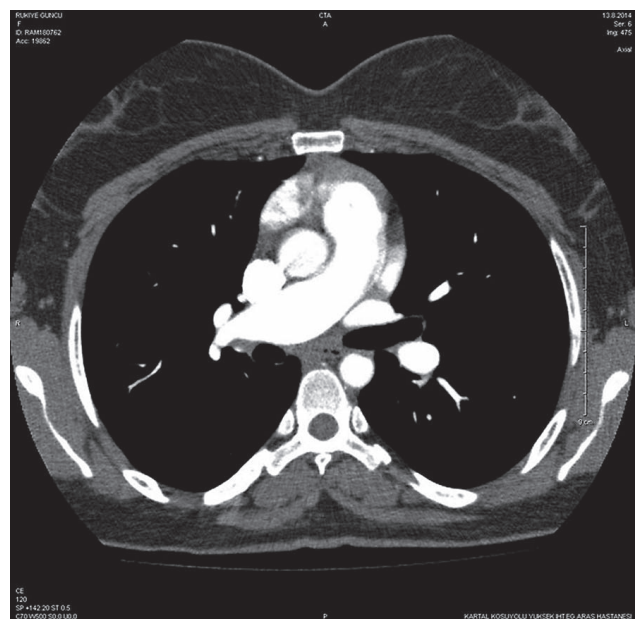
CT pulmonary arteriography, axial view showing distended pulmonary arteries compressing the arch of aorta.
